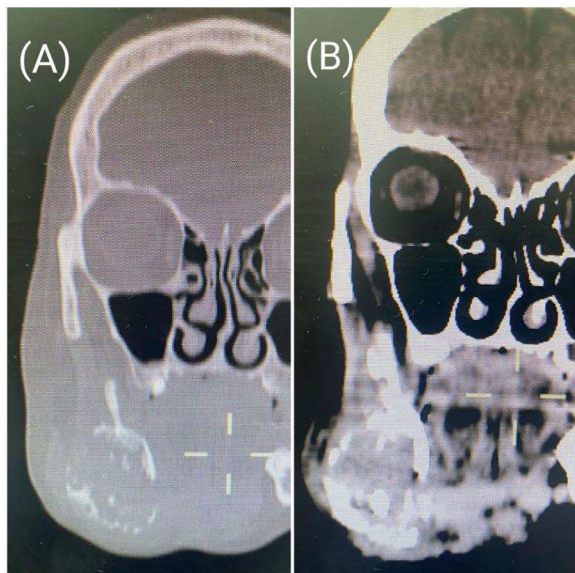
Coronal CT scan view (A) bone window (B) soft tissue window.
